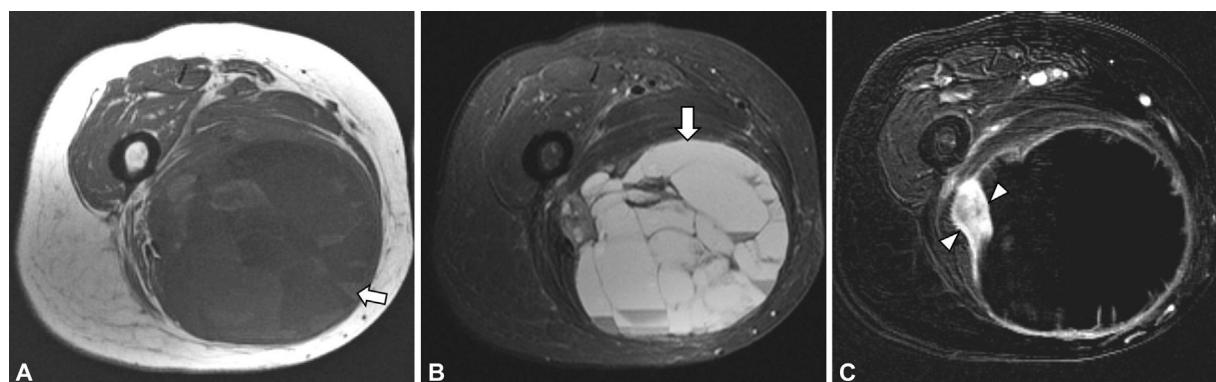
A 45-year-old man with enlarging thigh mass (arrows) without history of prior trauma. (A) Axial T1 magnetic resonance (MR) image shows a large heterogeneous mass in the medial thigh containing areas of high T1 signal compatible with blood products. (B) Axial short-tau inversion recovery (STIR) image shows heterogeneous hyperintensity within the mass with fluid-fluid levels. (C) Postcontrast subtraction MR image shows a nodular area (arrowheads) of enhancement in the periphery of the hematoma; a pleomorphic leiomyosarcoma on biopsy.
